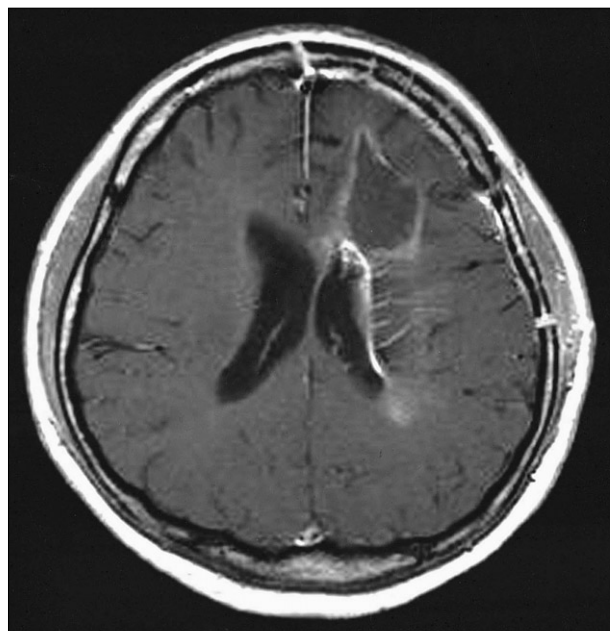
Postoperative gadolinium-enhanced axial magnetic resonance image showed no residual cavernous malformation with venous angioma being intact.
